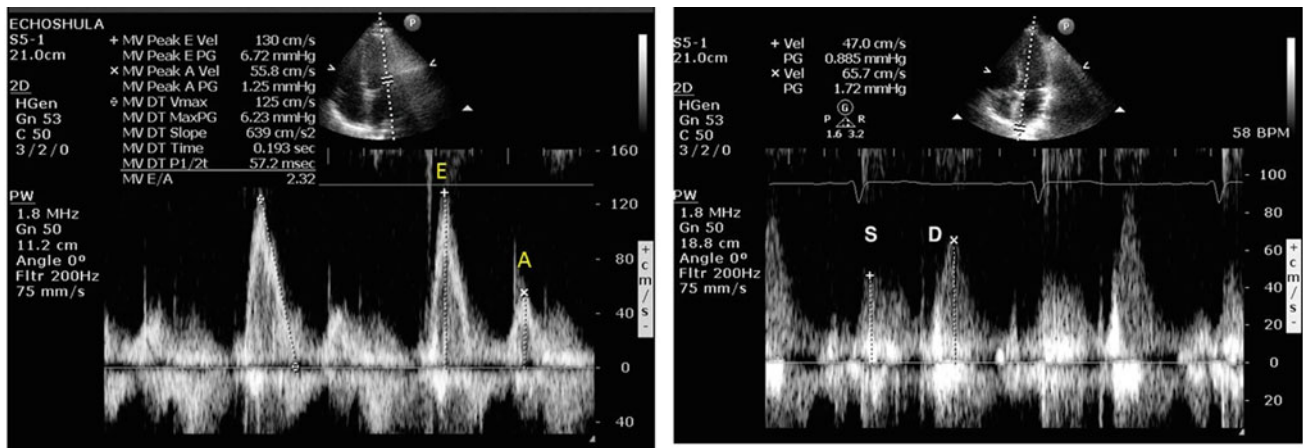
Left panel showing mitral inflow pulse Doppler tracing demonstrating elevated LV filling pressures (E/A ratio = 2.3), which is confirmed on the right panel showing pulmonary vein pulse Doppler (S < D)
